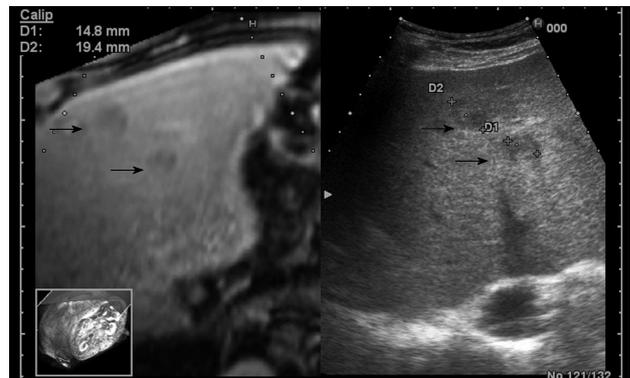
A 65-year-old male patient with liver metastases. The workstation monitor displays the ultrasound and computed tomography images in real-time.
